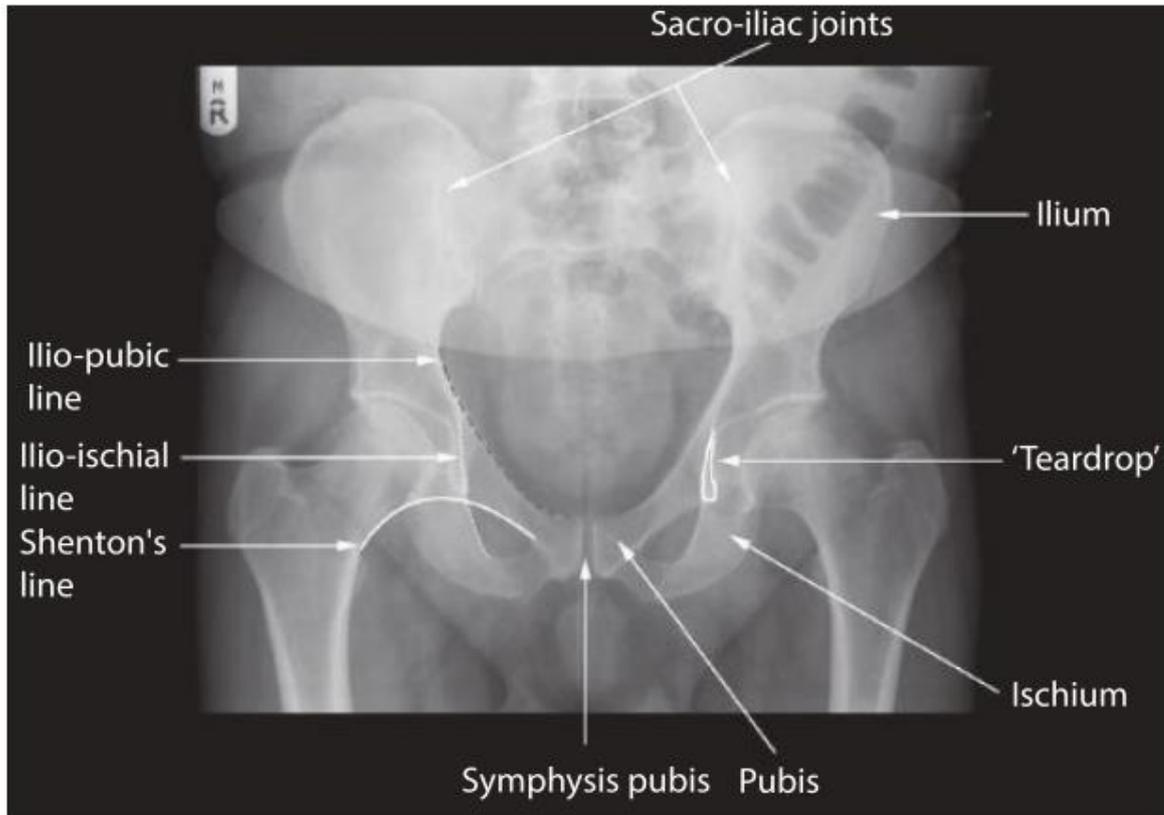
Radiological anatomy as seen on the AP pelvic X-ray image.
